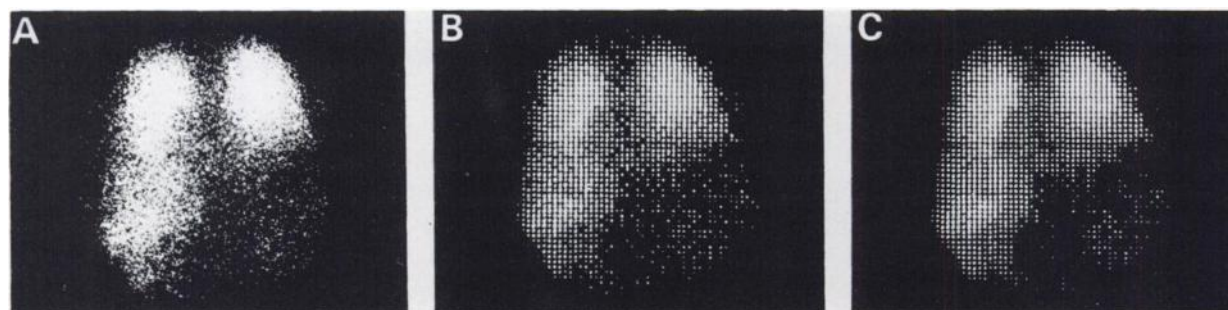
Gamma camera scintigram (A) suggesting multiple areas of reduced perfusion, secondary to bullous emphysema. 64 × 64 display (B) and computer "smoothed" display (C) are shown for comparison.
